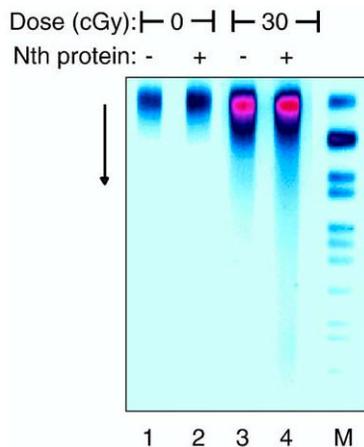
Electronic image of electrophoretic gel containing DNA from human cells not exposed to radiation (lanes 1 and 2) or exposed to 30 cGy 100-kVp X-rays (lanes 3 and 4). Companion agar plugs were incubated with (lanes 2 and 4) or without (lanes 1 and 3) Nth protein for detection of endogenous or radiation-induced Nth-oxypyrimidine clusters. M, molecular length standards; *S. cerevisiae* chromosomes.
